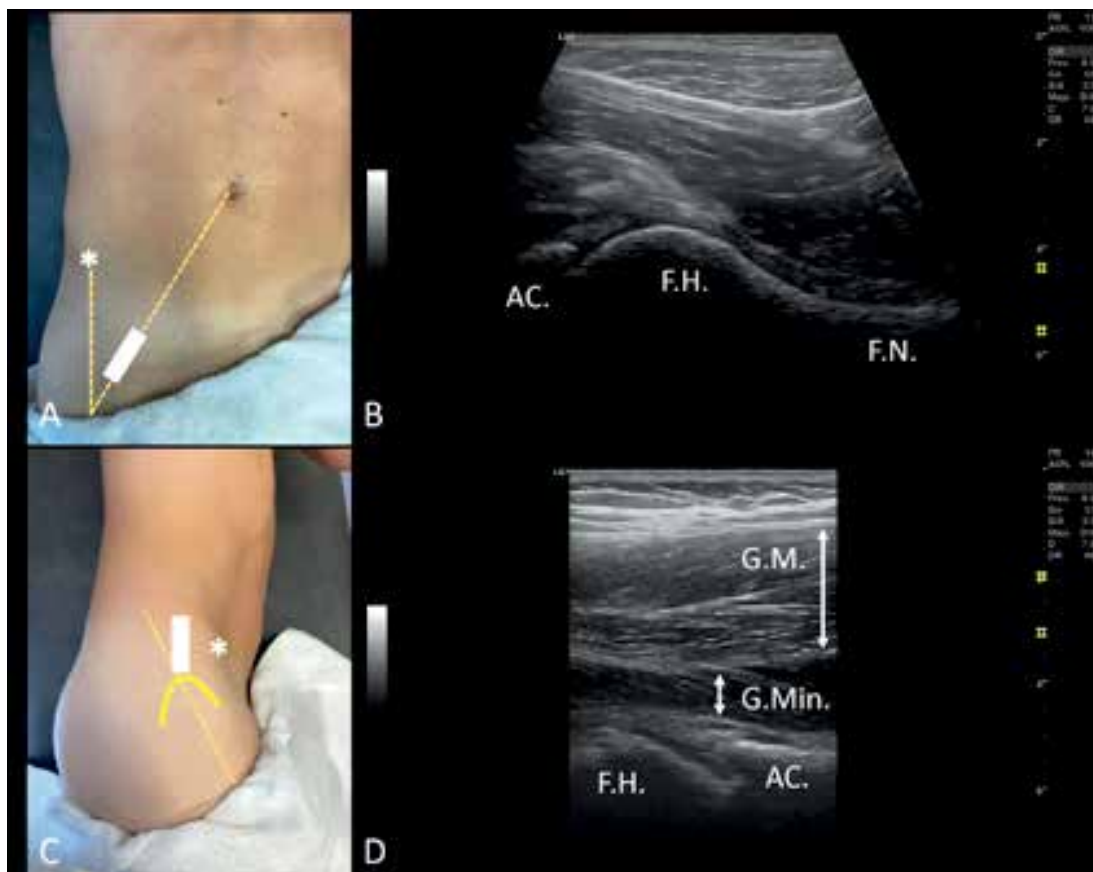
USI assessment and probe location of hip joint and gluteal muscles. Ultrasonographic evaluation of the hip and gluteus region. A – Probe location for longitudinal assessment of femoral hip alpha angle. B – Probe location for gluteus medius assessment at hip joint level; C – Hip joint view by virtual convex ultrasound mode; D – gluteus medius and minimus view at hip joint level
